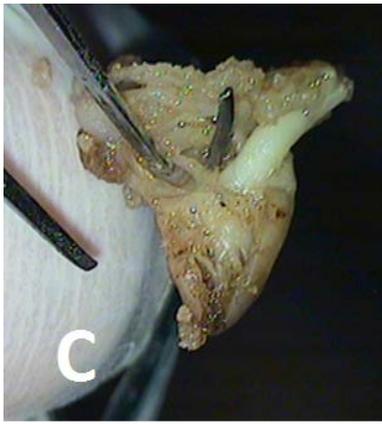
Atrio-ventricular septal defects (A, B). Color Doppler mode shows communication between the right and left side of the fetal hearth (open arrows).
